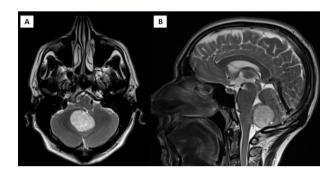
Brain MRI showing tumor in the posterior aspect of foramen magnum: (A) axial plane, (B) sagittal plane.
